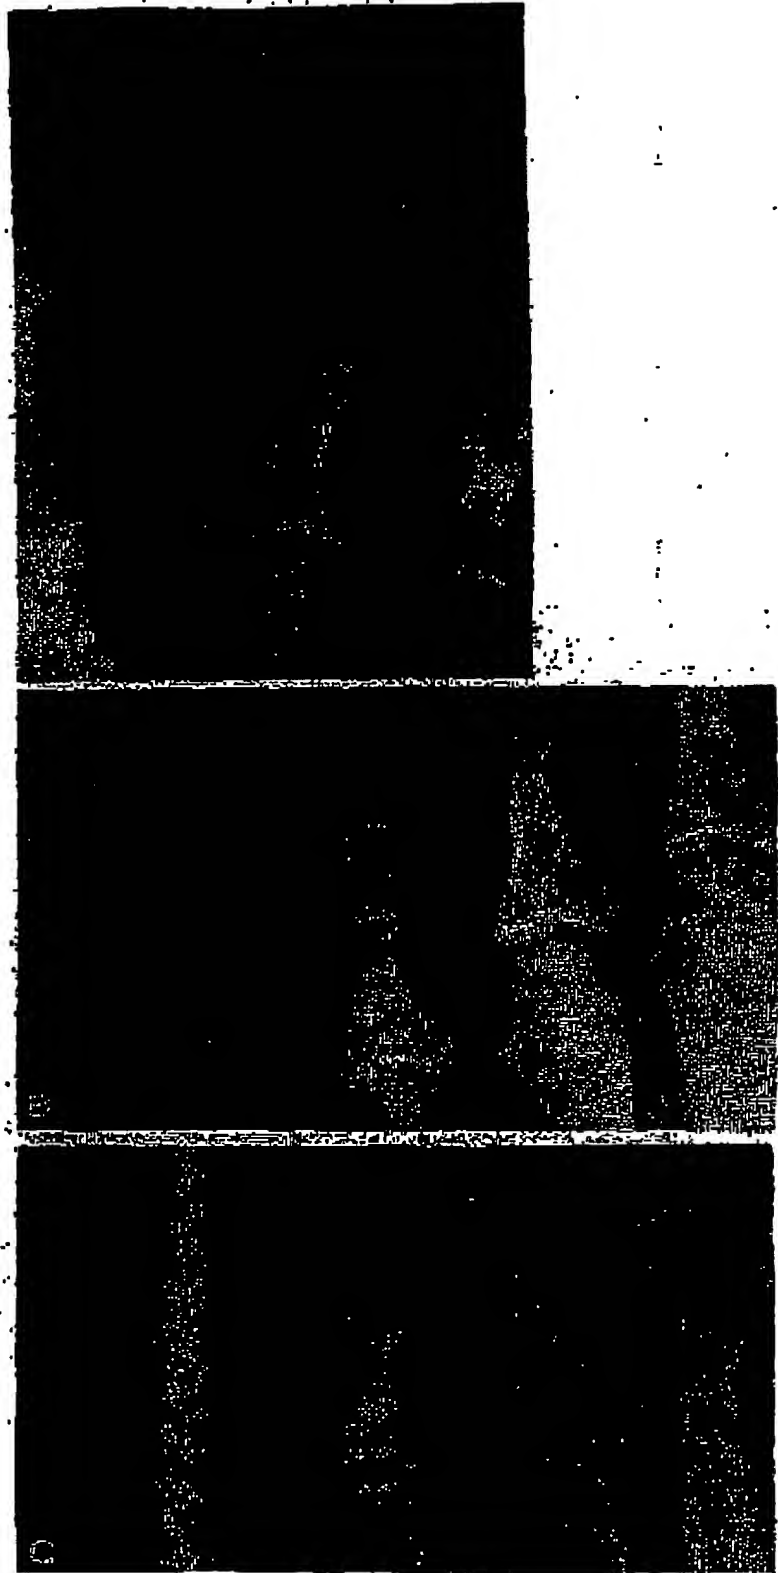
A, X-ray of Dow Corning implant in second toe. Note compression and bulging of implant. B, x-ray of Dow Corning implant in fifth toe. Note excessive size of central portion. C, another view of Dow Corning implant in fifth toe.
